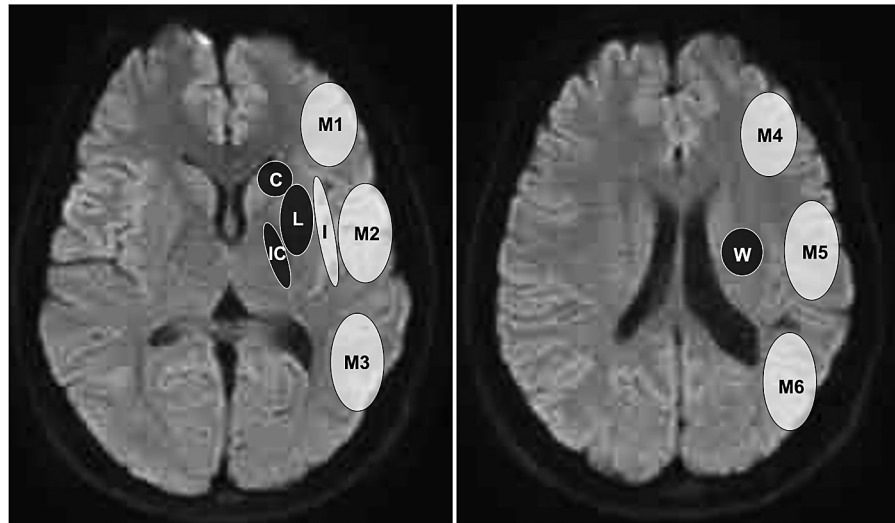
Diffusion-weighted imaging-Alberta Stroke Program Early CT score (DWI-ASPECTS) is divided into deep DWI-ASPECTS, which includes four structures (C, L, IC, and W), and cortical DWI-ASPECTS, which includes seven structures (I, M1, M2, M3, M4, M5, and M6). C represents the caudate nucleus; L, the lenticular nucleus; IC, the internal capsule; W, the deep white matter; I, the insular ribbon; M1, the anterior middle cerebral artery (MCA) cortex; M2, the MCA cortex lateral to the insular ribbon; M3, the posterior MCA cortex; and M4, M5, and M6, the anterior, lateral, and posterior MCA territories immediately superior to M1, M2, and M3.
